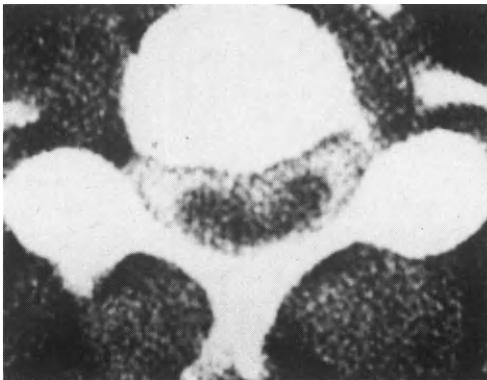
Spinal stenosis: CT with intrathecal metrizamide. The sagittal diameter of the spinal canal is developmentally small. The spinal cord is deformed by a small osteophyte on the posterior border of the 4th cervical body.
